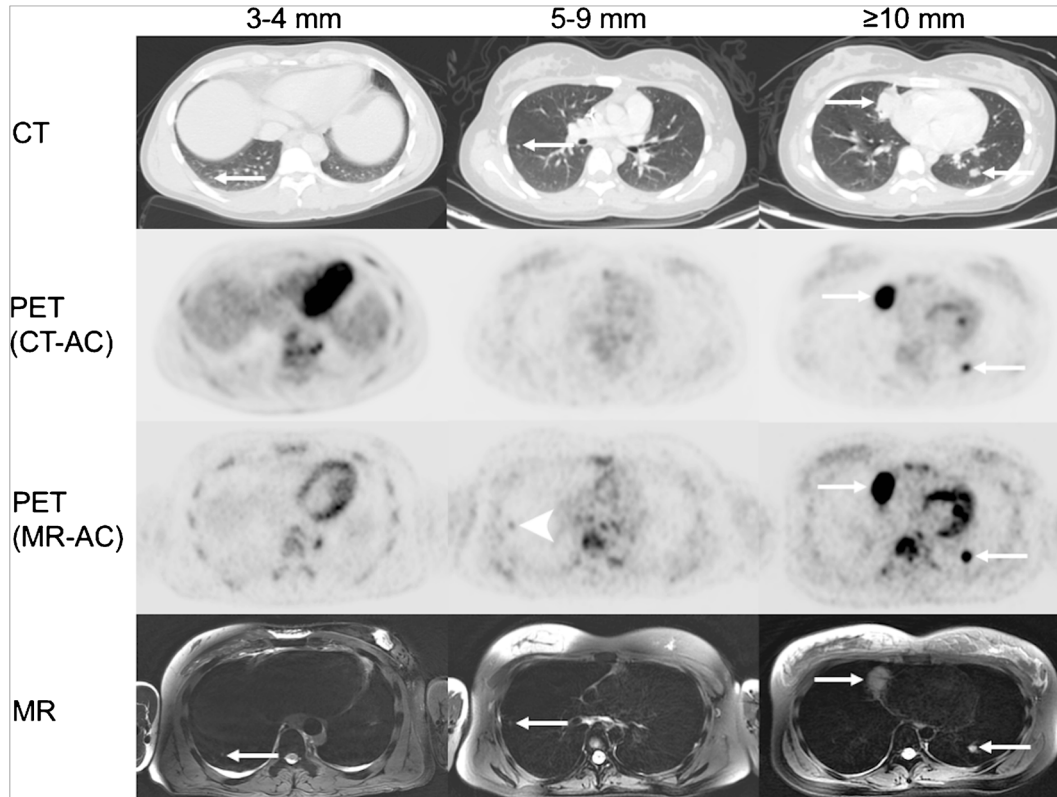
Detection of pulmonary nodules with PET/CT and PET/MR. Representative axial CT, PET (CT-attenuation corrected), PET (MR-attenuation corrected), and axial T2-weighted PROPELLER (TR/TE/Flip angle: 12,500/119/110) images of pulmonary nodules (white arrows) of different sizes. Improved detection of a 5 mm pulmonary nodule on PET scan of a PET/MR compared to PET scan of a PET/CT (white arrowhead).
